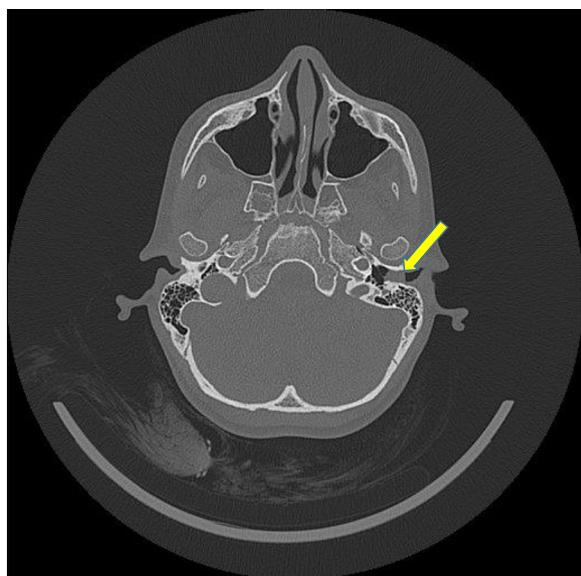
Axial CT scan view of the skull corresponding to the temporal bone region showing the lesion at EAC (yellow arrow) with obvious intact tympanic membrane, middle ear cavity, and well-pneumatized mastoid air cells
